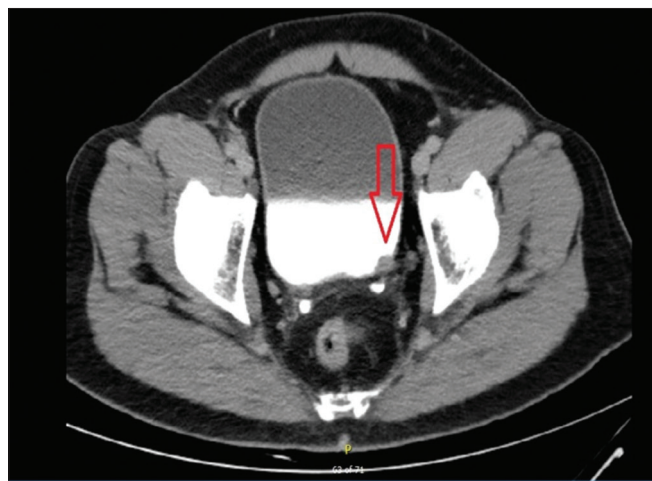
Triphasic CT scan of the urinary tract showing a confined bladder mass. CT: Computed tomography. The red arrows indicate areas of hypodensity in the renal parenchyma
